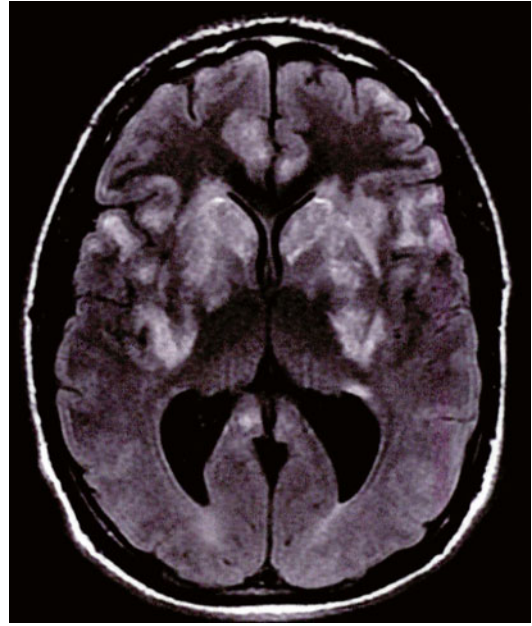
Case example: Viral encephalitis in a young adult: a 21-year-old college student who developed severe Epstein–Barr viral encephalitis. The patient had developed new eye discomfort with his soft contact lenses after starting a new contact lens solution; the problem did not remit despite switching brands of contact lenses. After 3 months of mild chronic discomfort, an extremely severe bilateral viral conjunctivitis developed over 10 days that resolved but then left the patient with myalgias and a stiff neck. Personality changes developed and progressed over the next 2 weeks, leading to being found in an unresponsive state with generalized seizure activity. Intravenous acyclovir was immediately started after a lumbar puncture revealed 35 nucleated cells per cubic microliter with 85 % lymphocytes. Initially, brain MRI was negative but within 6 days, marked limbic and basal ganglia signal changes were found, as also noted on hospital day 16. PCR analysis of a repeat CSF examination revealed low level presence of Epstein–Barr viral DNA. Despite the use of intravenous steroids, subcutaneous interferon beta1a, and the addition of cidofovir, and then switching over to intravenous ganciclovir, no significant clinical improvement was noted
